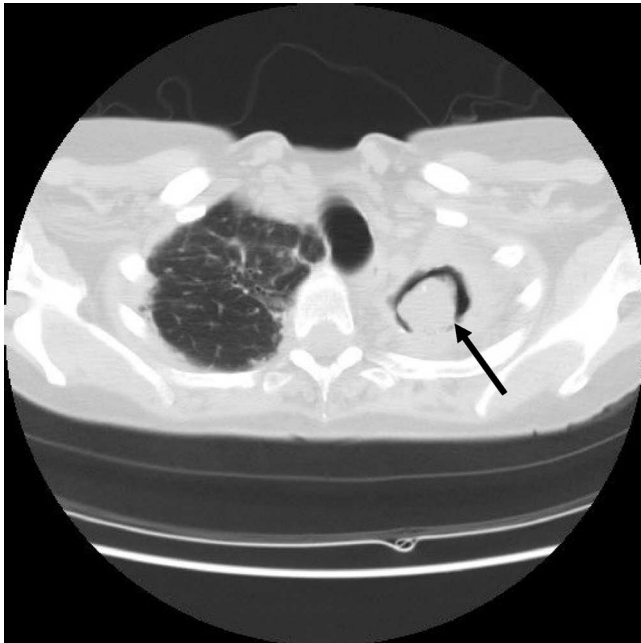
Aspergilloma (round mass in the left upper lobe) visualized by computed tomography in a young man. The etiology of the underlying cavity was unknown in this case.
